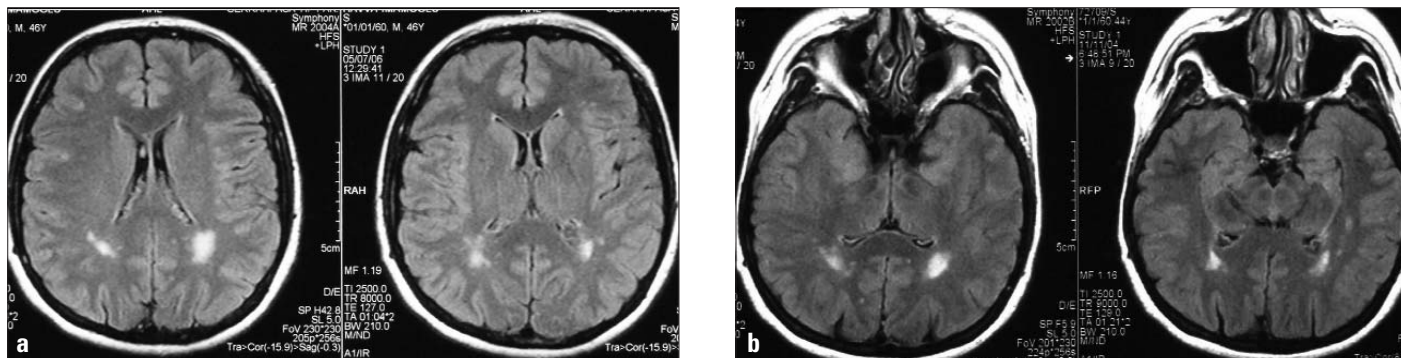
Cranial MRI study of the index case in 2004 (a) and 2006 (b) Axial FLAIR sequences
